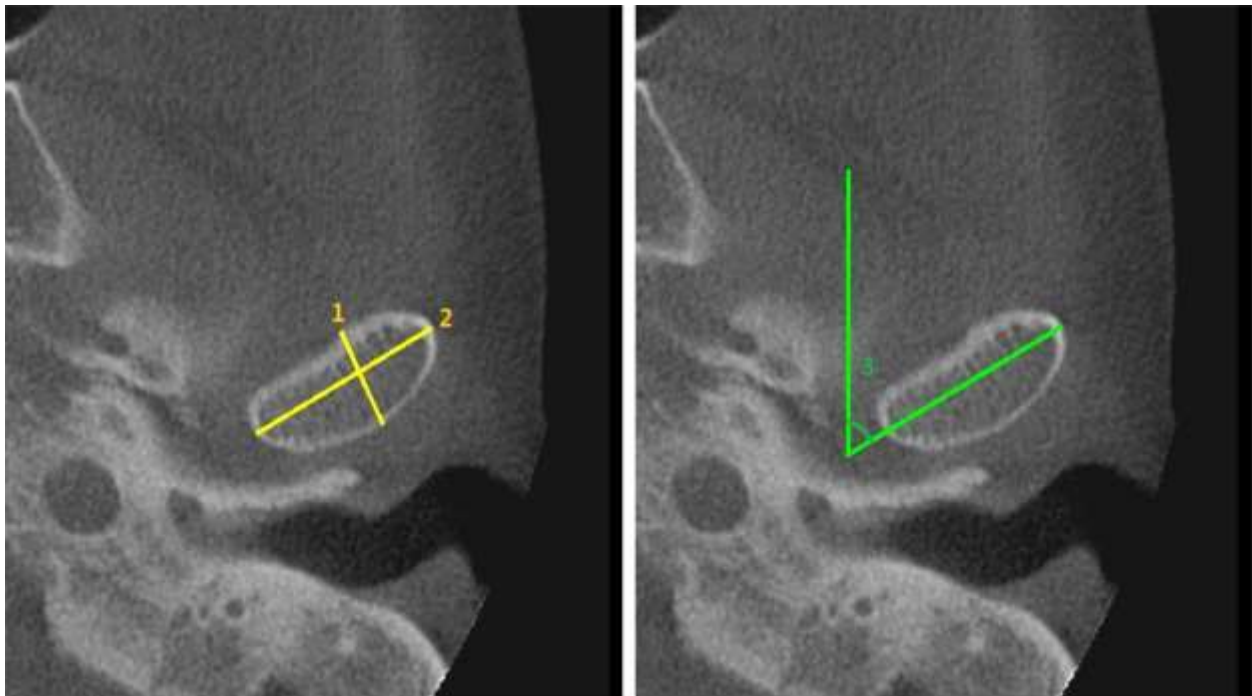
Axial measurements: 1, Anteroposterior width of the condylar process 2, Mediolateral width of the condylar process using i-CATvision CBCT software 3, Condylar head angle using ImageJ software.
